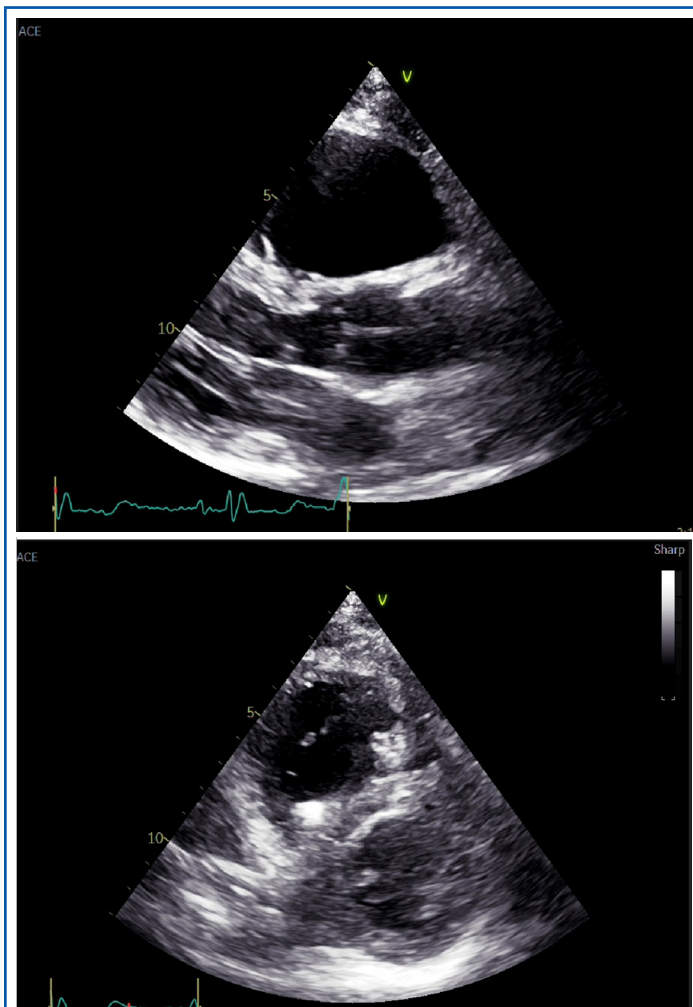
Transthoracic 2D echocardiography, parasternal (long and short axis) view of the RV, showing dilated RV. 2D, two-dimensional; RV, right ventricular.
